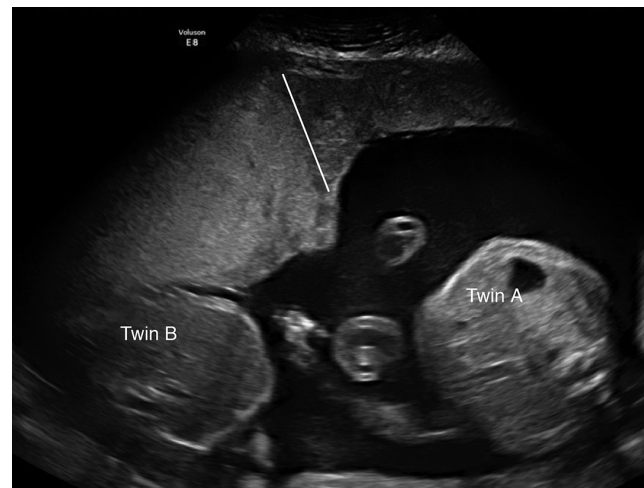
Transabdominal ultrasound image of pregnancy with twin anemia–polycythemia sequence, demonstrating discordant placental echogenicity and discrepancy in placental thickness (indicated by white line). Hypoechogenic thin area of anterior placenta belongs to polycythemic recipient Twin A and hyper-echogenic thickened part belongs to anemic donor Twin B.
